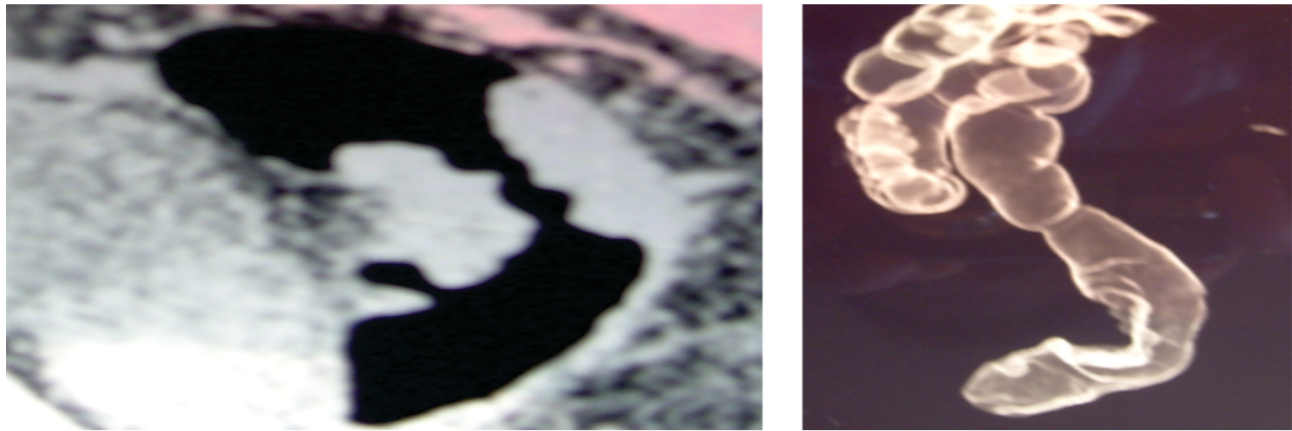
CT colonography performed at the PHI University Clinic of Radiology, Skopje, in a 85 year- old patient. The two dimensional sagittal CT image reveals a circumferential rectum cancer confirmed by biopsy. The reformatted picture "in space", reveals a polyp on a broad basis distal to the tumor. The application of iv contrast allows detection of metastatic disease. In this review no meta-stases were identified.
